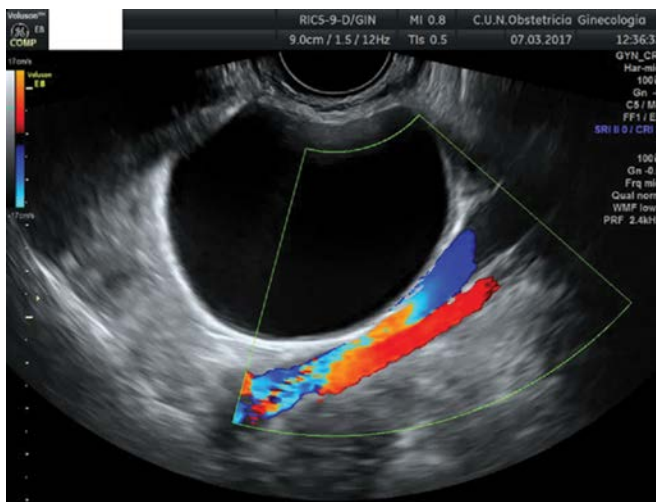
Transvaginal ultrasound showing the typical appearance of a pelvic lymphocele in a woman with a past history of radical hysterectomy plus pelvic lymphadenectomy for a cervical cancer.
